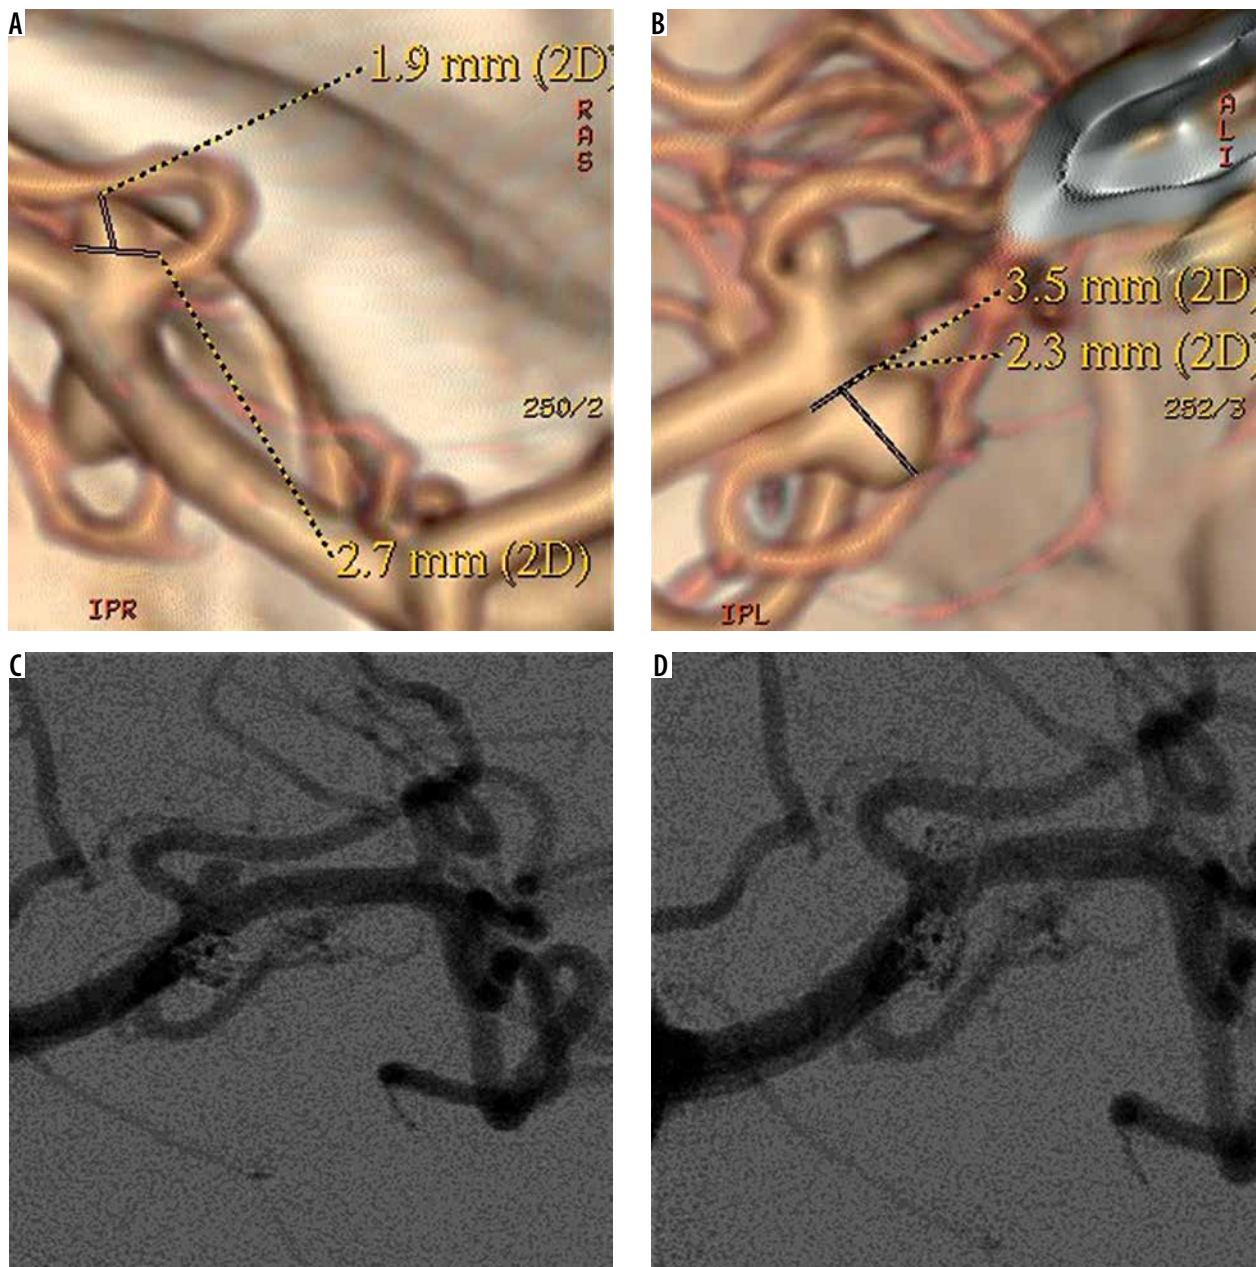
53-year-old female patient presented with two small unruptured middle cerebral artery (MCA) aneurysms. A, B) Computed tomography angiograms showed two small (< 5 mm) MCA aneurysms. C, D) Control digital subtraction angiography following endovascular coiling, showed the complete occlusion of the two aneurysms. Follow-up angiogram (not shown) performed after 78 months confirmed the complete obliteration of the lesions
